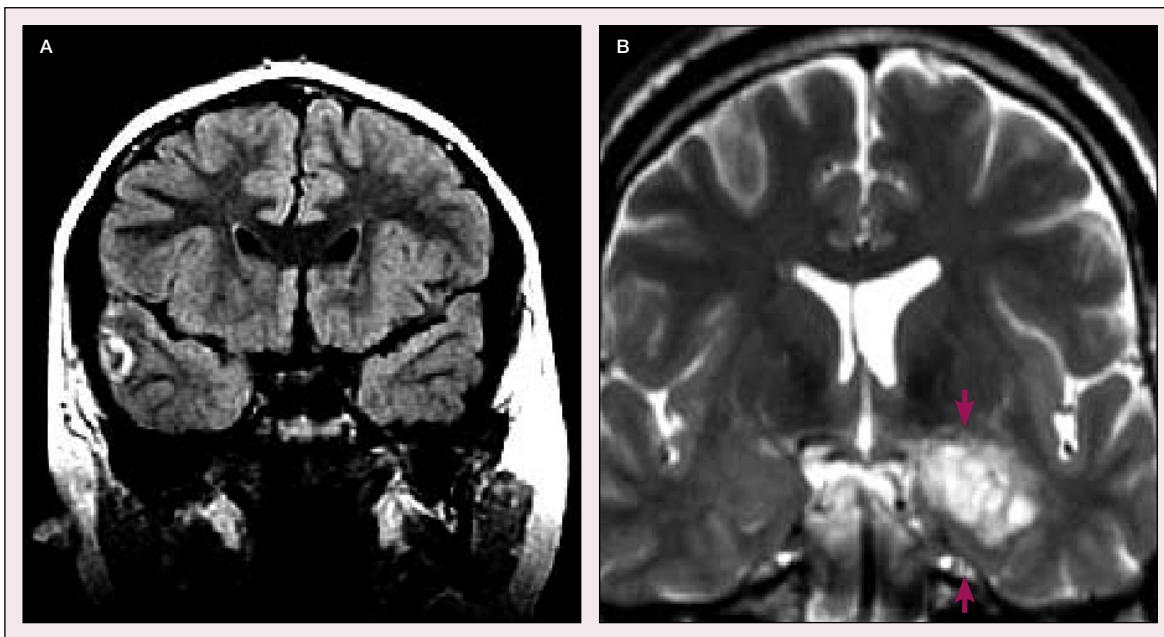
(A) Coronal FLAIR MRI showing a discrete ring-like lesion in the lateral aspects of the right middle temporal gyrus consistent with a small neoplasm. Pathology revealed a dysembryoplastic neuroepithelial tumour. (B) Coronal T2-weighted MRI showing a large dysembryoplastic neuroepithelial tumour occupying most of the left mesial temporal lobe.
